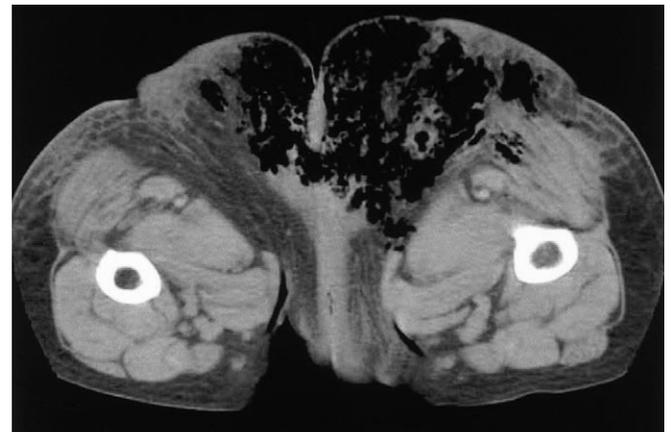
Case 3. Pelvic computed tomography revealed an extensive gas shadow in the subcutaneous space of the buttocks.
